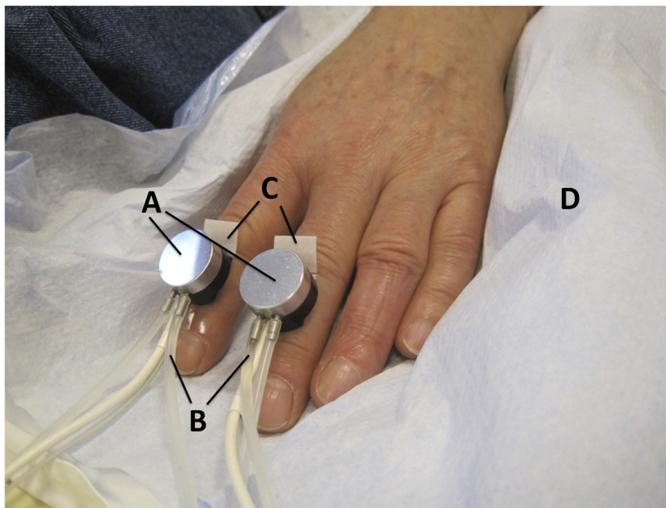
Single-point laser Doppler probes (A) with a liquid cooling system made of silicon tubes (B). C: probes were fixed with double-sided tape. D: a vacuum cushion was used to decrease artifacts associated with arm movements.
